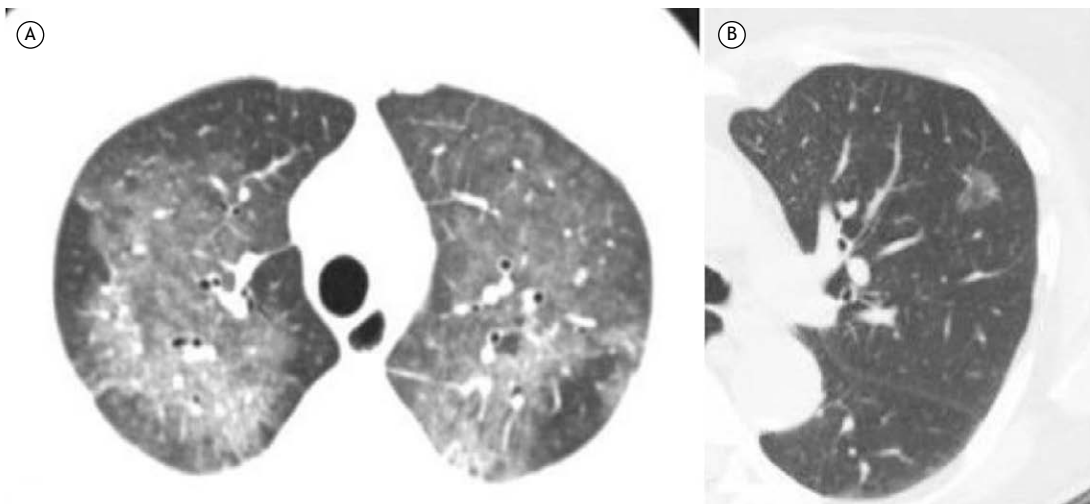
Axial CT scans with lung window settings demonstrating ground-glass opacities and predominant central distribution in both lungs in a patient with pulmonary edema (A) and revealing a ground-glass (subsolid) nodule that was diagnosed as lepidic growth adenocarcinoma (B).
